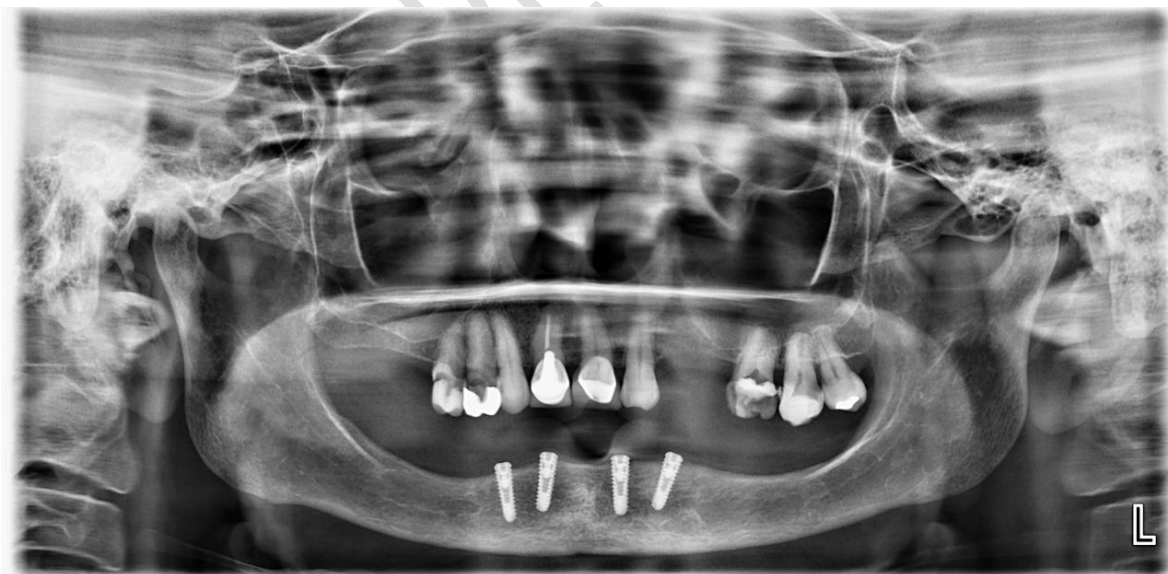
Panoramic radiograph one year after implant placement. There is minimal vertical bone decrease around the implants, there is no peri-implant bone loss, and no pathological anatomical changes are located.
